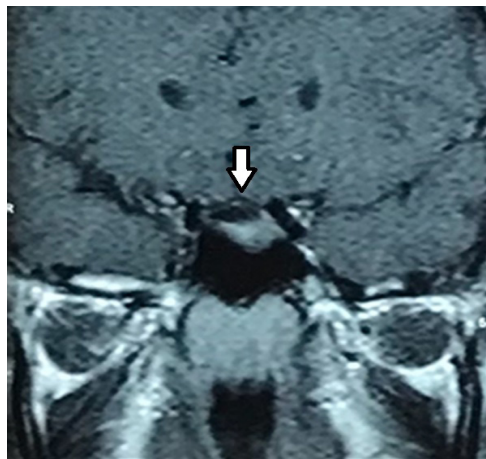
At 1-year post treatment, the MRI showed reduction in the suprasellar mass size (arrow)
